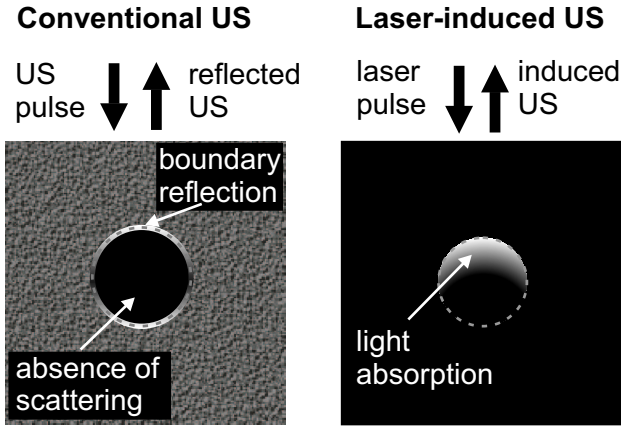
Imaging of blood-vessels (dashed circles) using conventional and laser-induced ultrasonography. US = ultrasound. The blood-vessel appears in the ultrasonic B-scan image as a black circle with white boundaries. The dark area corresponds to an absence of acoustic scatterers (acoustic homogenous blood). The boundaries reflect the ultrasound. In laser-induced ultrasound imaging, the laser pulsed is mainly absorbed by the blood inside the vessel. This leads to an exponentially distributed instantaneous heating, which generates the ultrasonic pulse. Depending on the absorption depth to vessel diameter ratio, blood vessels are either generate "half moons" ($\lambda=590$ nm) or whole disks (NIR wavelengths) pressure signals.
